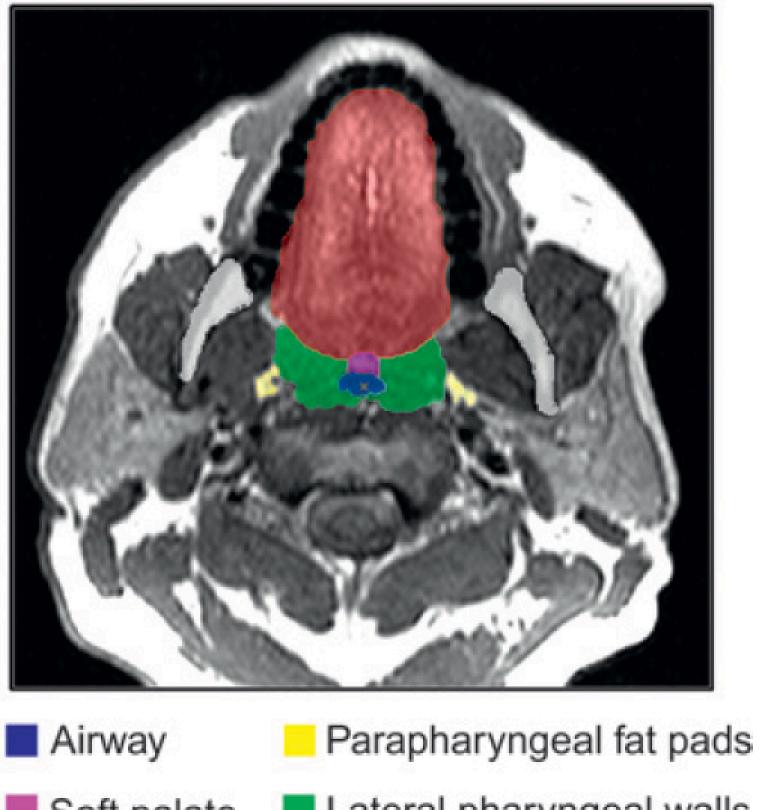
(A) Segments of the upper airway on mid-sagittal MRI: velopharynx (from the hard palate to the tip of the uvula), oropharynx (from the tip of the uvula to the tip of the epiglottis) and hypopharynx (from the tip of the epiglottis to the level of the vocal cords). (B) Segmentation of upper airway structures on axial MRI: airway lumen, parapharyngeal fat pads, soft palate, tongue (genioglossus) and lateral pharyngeal walls.
